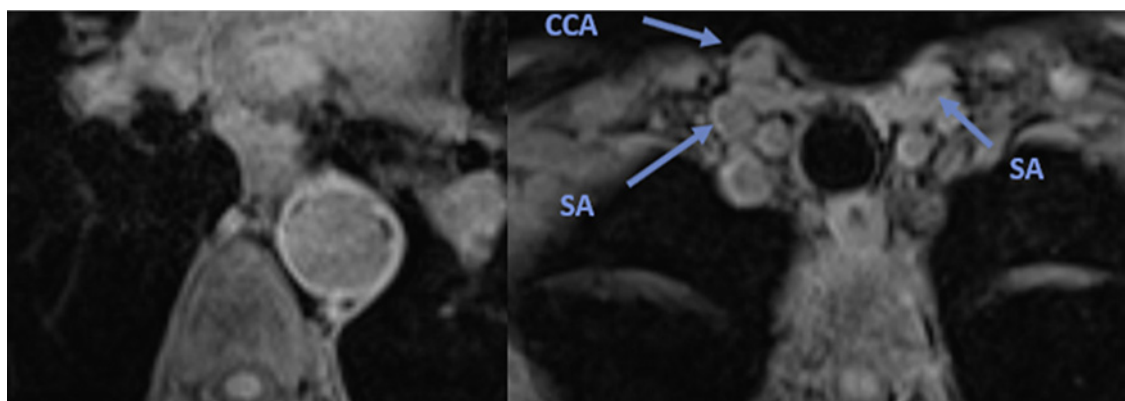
MRI showing gadolinium enhancement of vessel wall: descending aorta (left), subclavian artery (SA) on both sides (right picture), and common carotid artery (CCA).
